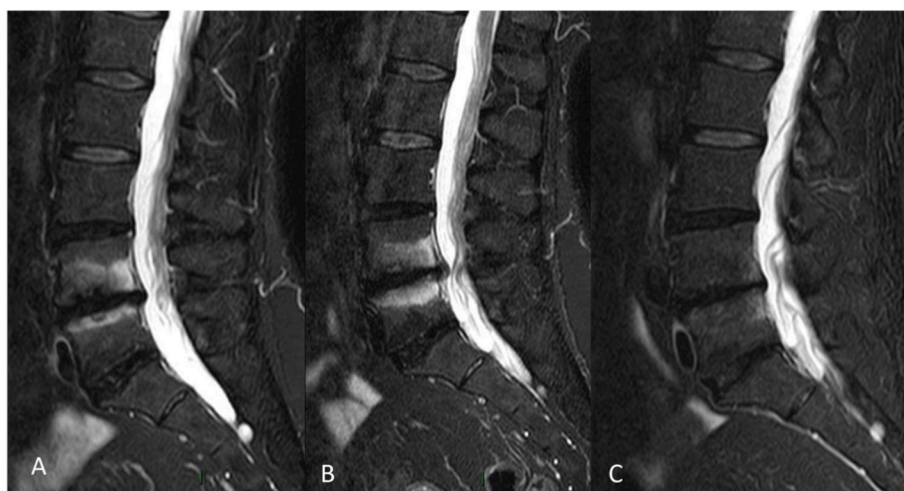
Fat suppression on the sagittal plane MRI examination, before (A), 1 year after pharmacological treatment (B) and at six month after oxygen-ozone therapy (C).
